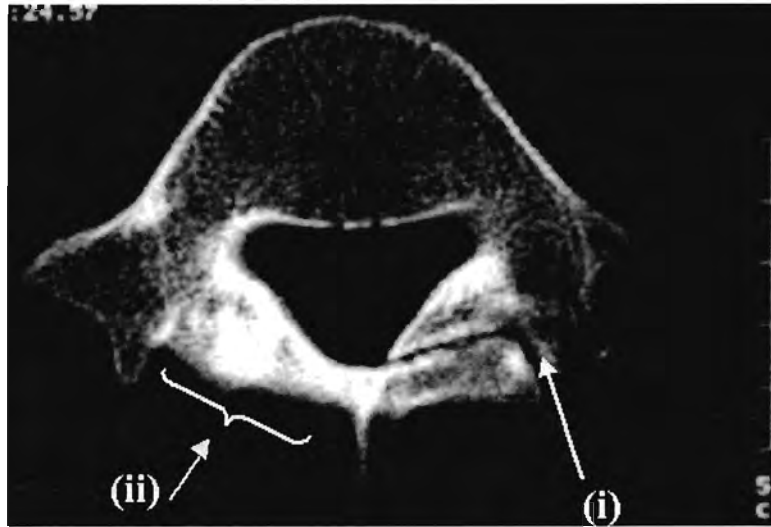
A CT scan of a 22-year-old right bowler of national ranking (subject 8) showing (i) non-union of the left pars interarticularis fracture and (ii) a bony thickening of an old fracture of the right pars interarticularis of the 5th lumbar vertebra. There is also thickening of the right pedicle of the 5th lumbar vertebra. He did not miss any matches due to back pain during his national career.
